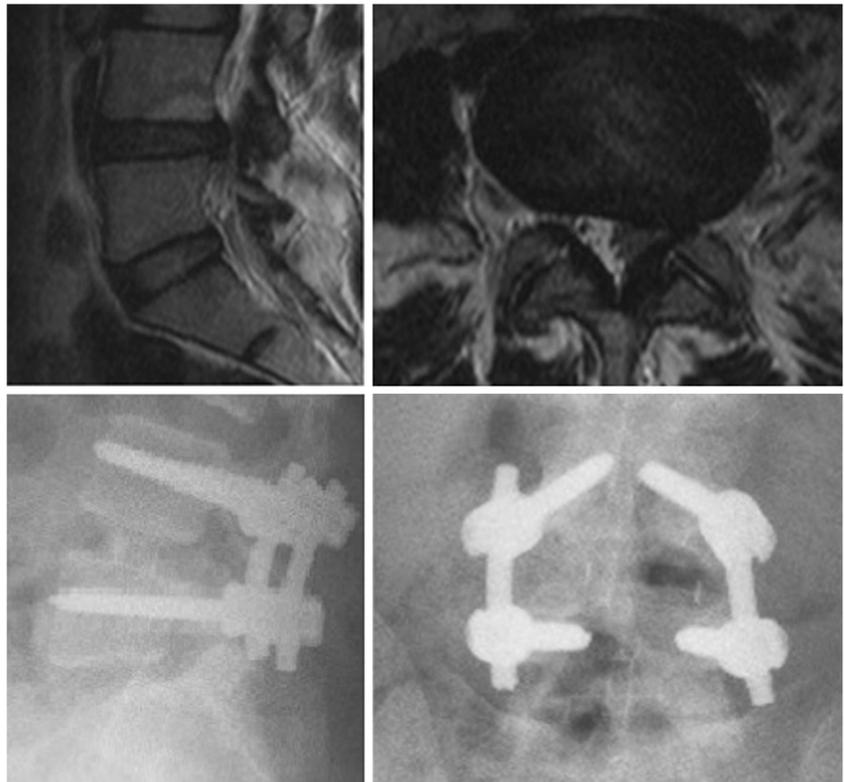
Preoperative MRI and postoperative X-ray images of the patient in whom titanium cage was used
